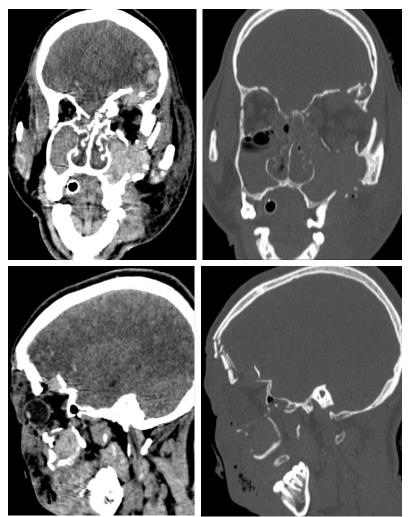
Head CT coronal and sagittal planes, on parenchymal et bone window
